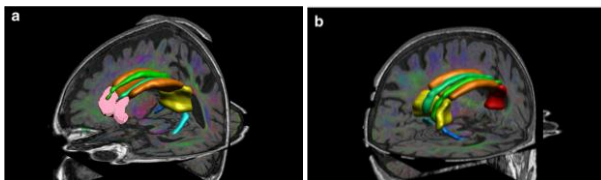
A 3D MR images of a subject's regions of interest projected over the fused colour coded fractional anisotropy and T1 weighted images.
